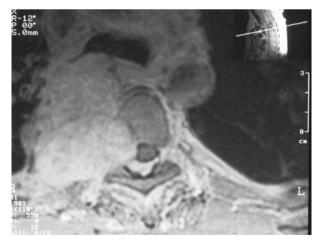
Direct spine invasion by a lung cancer: axial plan MRI T1 sequence with gadolinium
